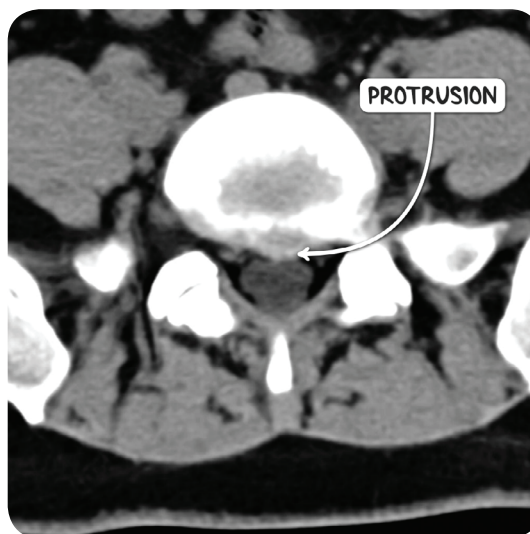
An MRI scan of the spine.
